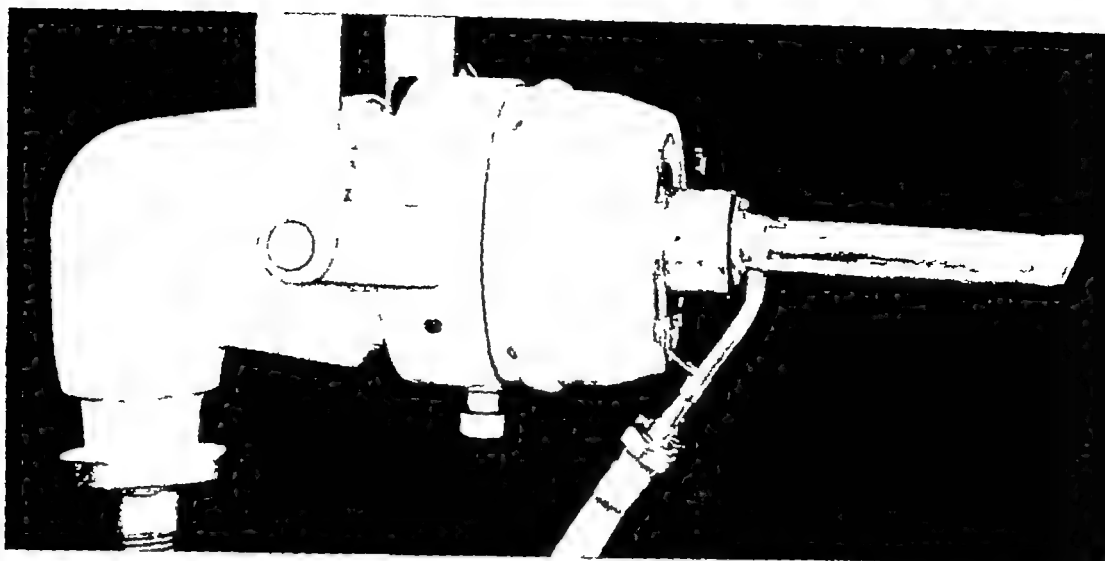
The cone of Chaoul apparatus contact or short-distance x-ray therapy apparatus Transmission anode
